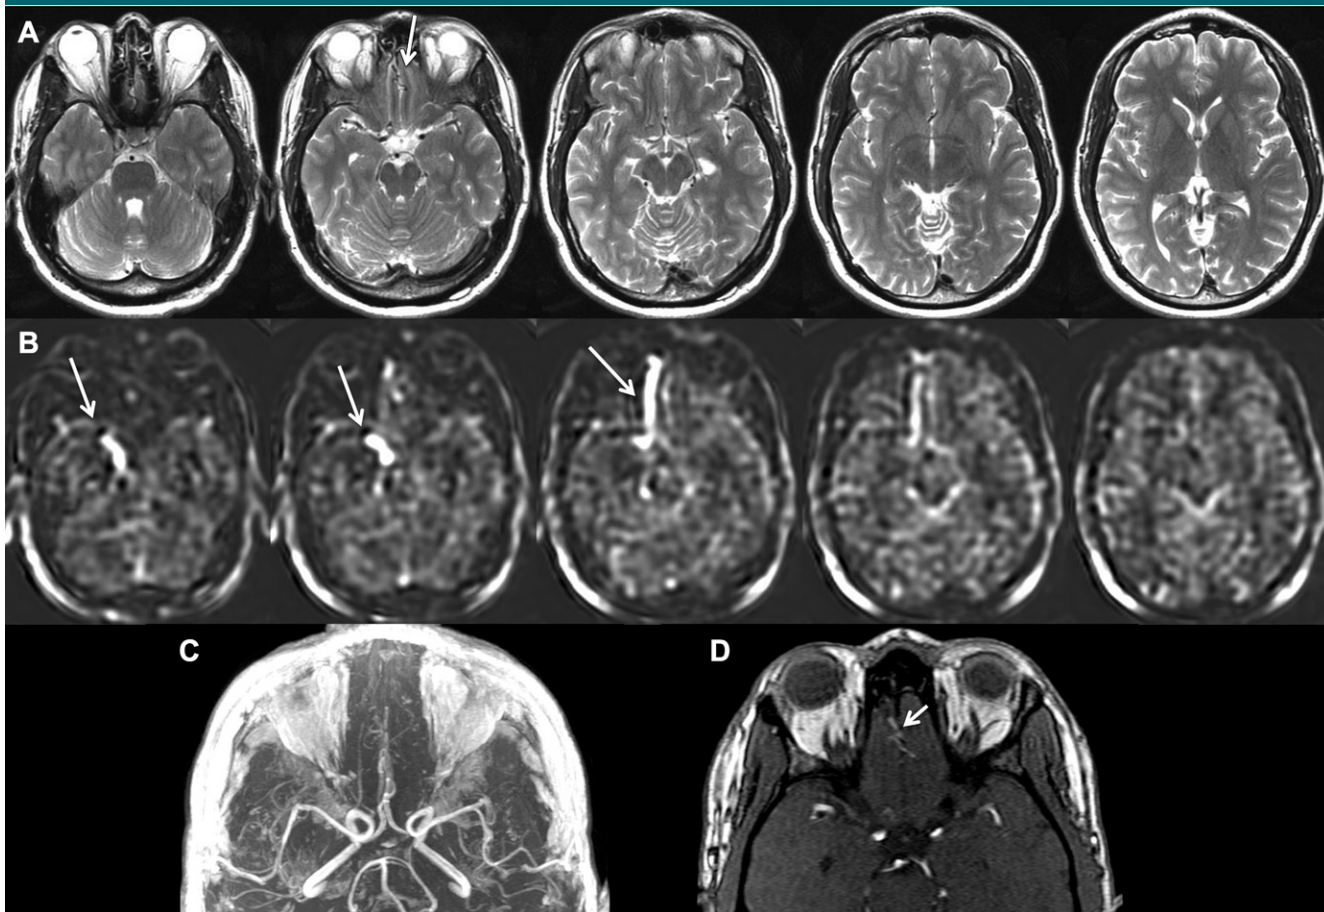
Images in 51-year-old man with exertional headaches and an arteriovenous fistula imaged at 1.5 T. *A*, T2-weighted images demonstrate very subtle flow voids in the inferior frontal lobe (arrow). *B*, ASL images demonstrate linear high signal intensity (arrows) in the region of the right inferior frontal lobe, which extends to the right cavernous sinus, indicative of an arteriovenous shunt lesion. *C*, Collapsed and, *D*, source MR angiographic images confirm the presence of an ethmoidal dural fistula (arrow), which was recognized only after the observation of the abnormal ASL signal within the venous structures draining the fistula. This case also demonstrates that while 3 T is preferable to 1.5 T, relevant clinical information can be obtained with ASL at 1.5 T.
